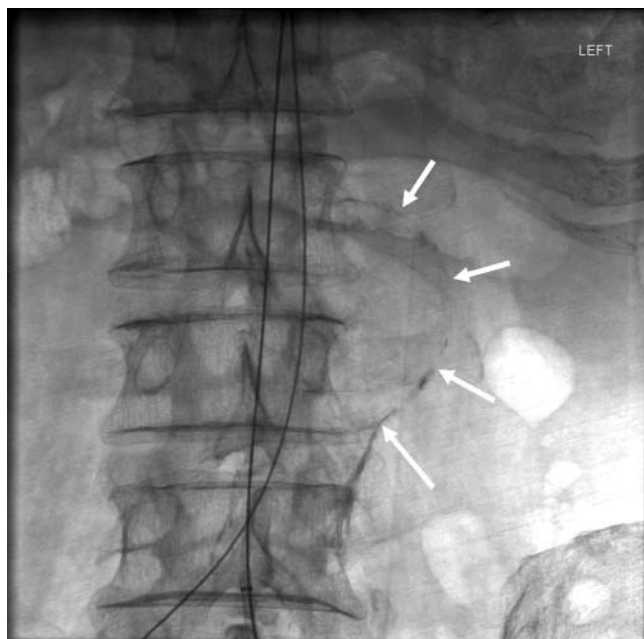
Plain abdominal x-ray for the diagnosis of aneurysms. Noncontrast x-ray film of the abdomen demonstrating the calcified outline (arrows) of an abdominal aortic aneurysm.
